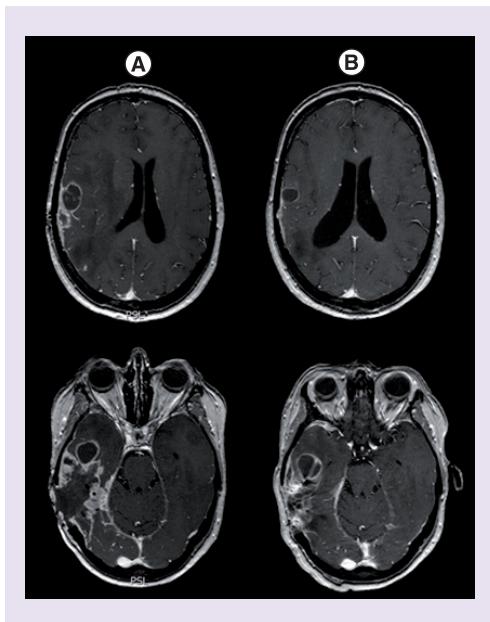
Interval MRI. Above: T1 sequences with Gadolinium, below: T2 sequences at baseline (A) and 4 months after commencement of dabrafenib and trametinib (B) demonstrating reduction in solid disease, cystic disease and mass effect.
